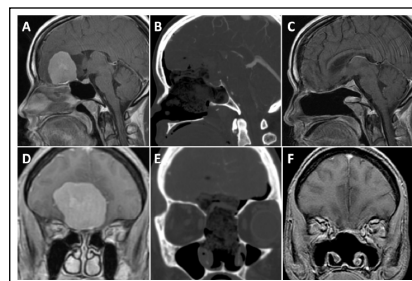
A and D: Preoperative sagittal (A) and coronal (D) T1-weighted Gd-enhanced MRI demonstrating a large olfactory groove meningioma that was resected using an endoscopic endonasal transcribriform approach with subsequent repair using the triple-layer reconstruction technique. B and E: Postoperative sagittal (B) and coronal (E) CT scans demonstrate a large anterior skull base defect extending from the frontal bone to the sella turcica in the sagittal view and from the medial orbit to the medial orbit in the coronal view. C and F: Postoperative MRI at 1 year demonstrates excellent reconstruction of the anterior cranial base without recurrent tumor.
